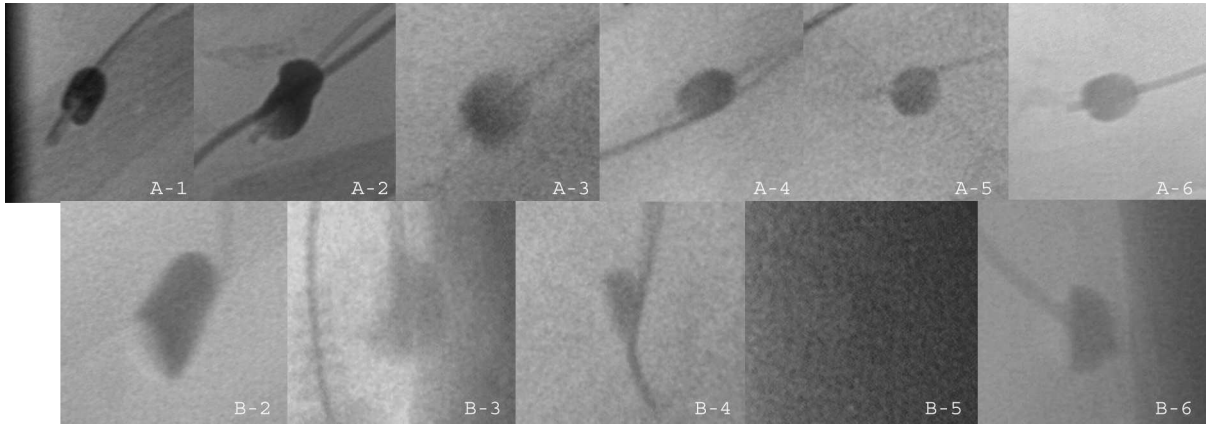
Examples of intravascular balloon catheters as seen using x-ray fluoroscopy. The top row of images contains views along the PA ( $A-x$ ) axis, while the bottom row of images includes views along the lateral (LAT,  $B-x$ ) axis. Series 1 was only captured from the PA perspective; all others are paired images. All images were gathered intraoperatively under an IRB-approved protocol.
